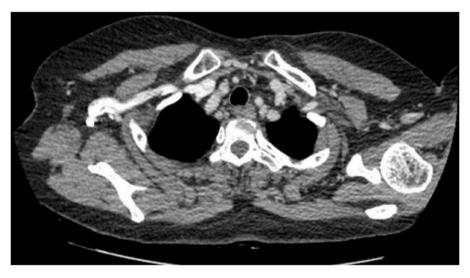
On computed tomography image of the patient after treatment: no bilateral axillary lymph nodes.
